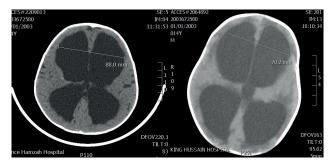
a) preoperative CT scan, b) postoperative CT scan showing the reduction in ventricular system ${\bf r}$
